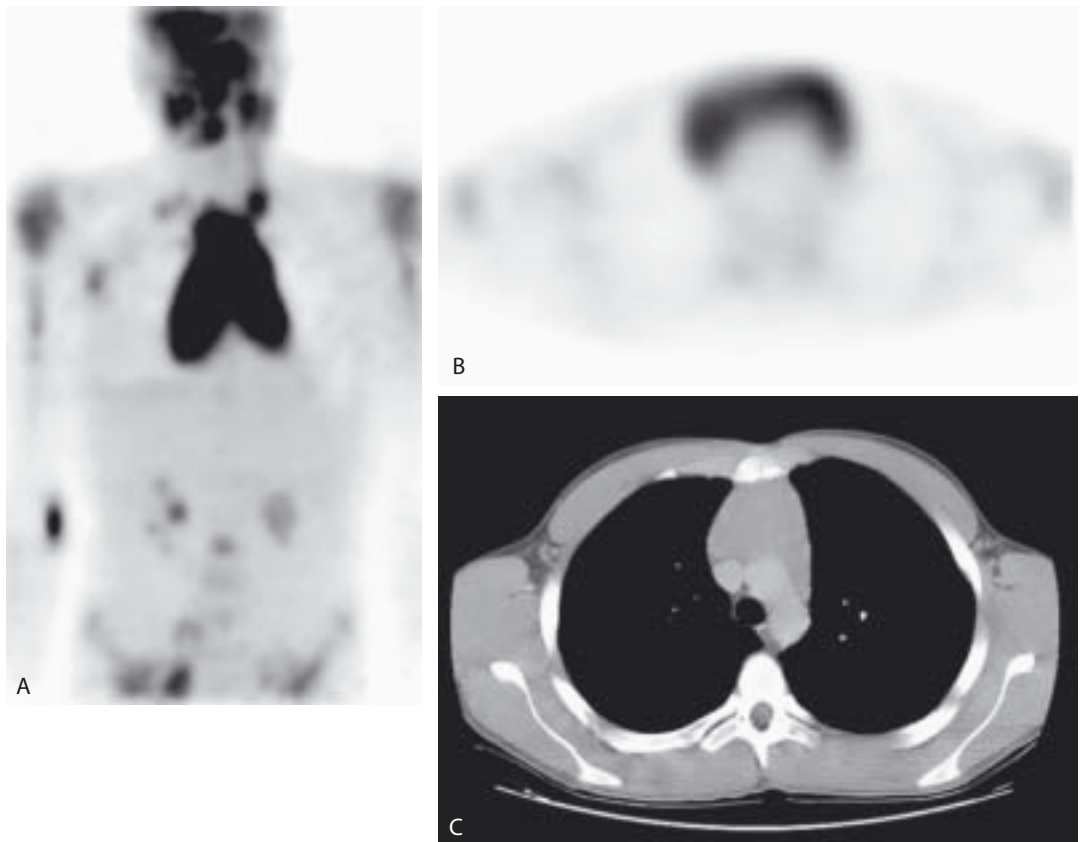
A: A PET image of a 16-year-old boy with stage IV T-cell lymphoblastic lymphoma shows numerous fluorodeoxyglucose (FDG)-avid lesions including a very large, hypermetabolic focus in the mediastinum. An axial image (B) shows the retrosternal location of this abnormality, which corresponds to lymphomatous infiltration of the thymus identified on the CT scan (C). Compare both the extent and intensity of thymic FDG uptake in this patient with lymphomatous involvement of the gland to that in the normal thymus gland in Figure 12.1.
